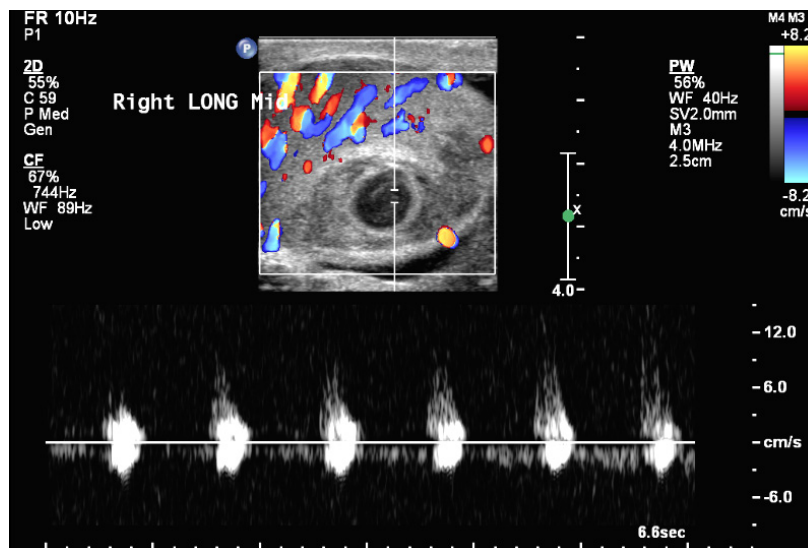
Doppler ultrasound of the right testicle in transverse reveals an arterial waveform within the center of the anechoic portion of the testicular mass.
